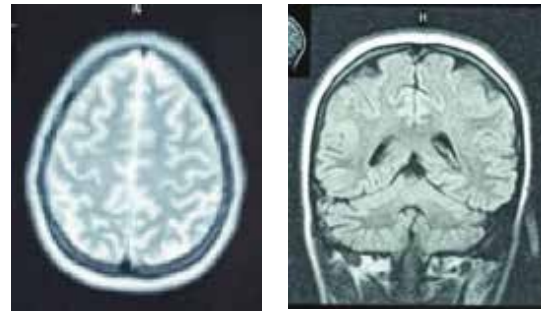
MRI brain plain.
